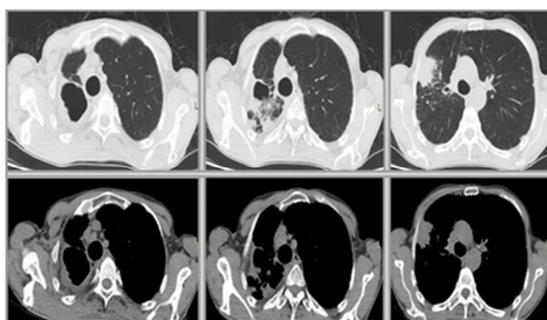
Thorax CT slices of first admission
